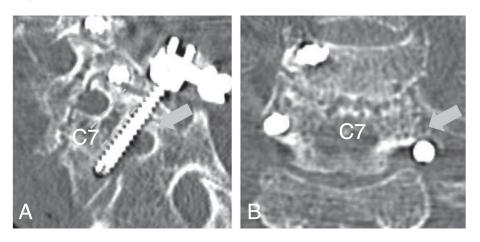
Parasagittal CT image (A) and coronal CT image (B) at C7 detected lateral deviation of Grade 2 on left CPS. Mild postoperative numbness of the left finger was noted but improved over time.
